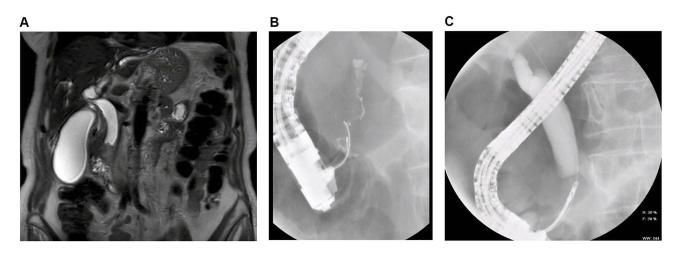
A 84-year-old woman presenting painless jaundice. TUS showed CBD and intrahepatic bile duct dilatation. MRI showed a suspected 22mm intraductal mass at the distal part of the CBD with an upstream dilatation (A). EUS-FNA confirmed an intraductal mass in the CBD suggestive of cholangiocarcinoma. ERCP revealed a long, irregular, distal biliary stricture (B); brushing and intraductal forceps biopsies confirmed the presence of malignant cells (C). Abbreviations: TUS, transabdominal ultrasound; CBD, common bile duct; MRI, Magnetic resonance imaging; EUS-FNA, endoscopic ultrasound fine needle biopsy; ERCP, Endoscopic retrograde cholangiopancreatography.
